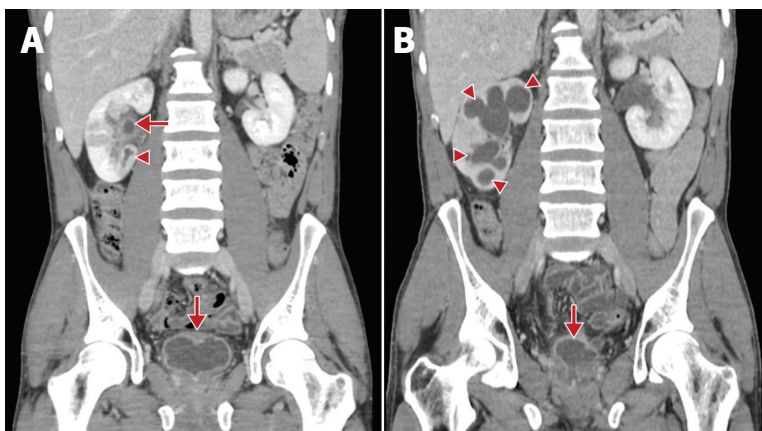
Computed tomography scans from a 37-year-old man with urinary tract tuberculosis. (A) Scan from first presentation, showing an abscess of the lower pole of the right kidney (arrowhead), and thickening of the renal pelvis and bladder walls (arrows). (B) Scan from 3 months after starting treatment for tuberculosis, showing progression of right hydronephrosis (arrowheads) and severe shrinkage of the bladder (i.e., thimble bladder) (arrow).
